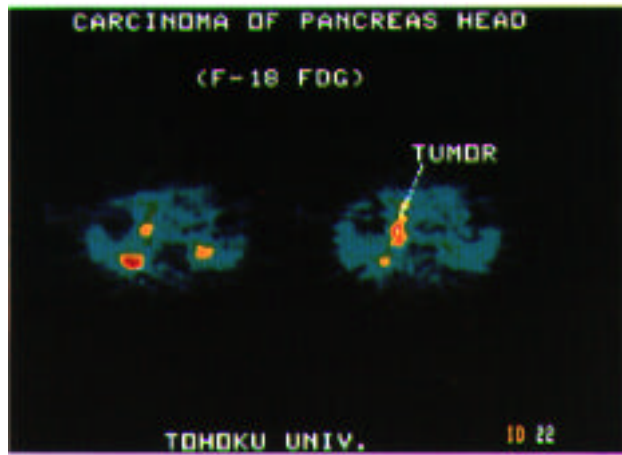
(a) X-CT of a pancreatic cancer. An abnormal mass was observed in the head of pancreas. (b) Positron tomogram of this case 50 min after ^{18}F FDG injection. High activity was seen in the head tumor. Bilateral kidney showed very high activity.
